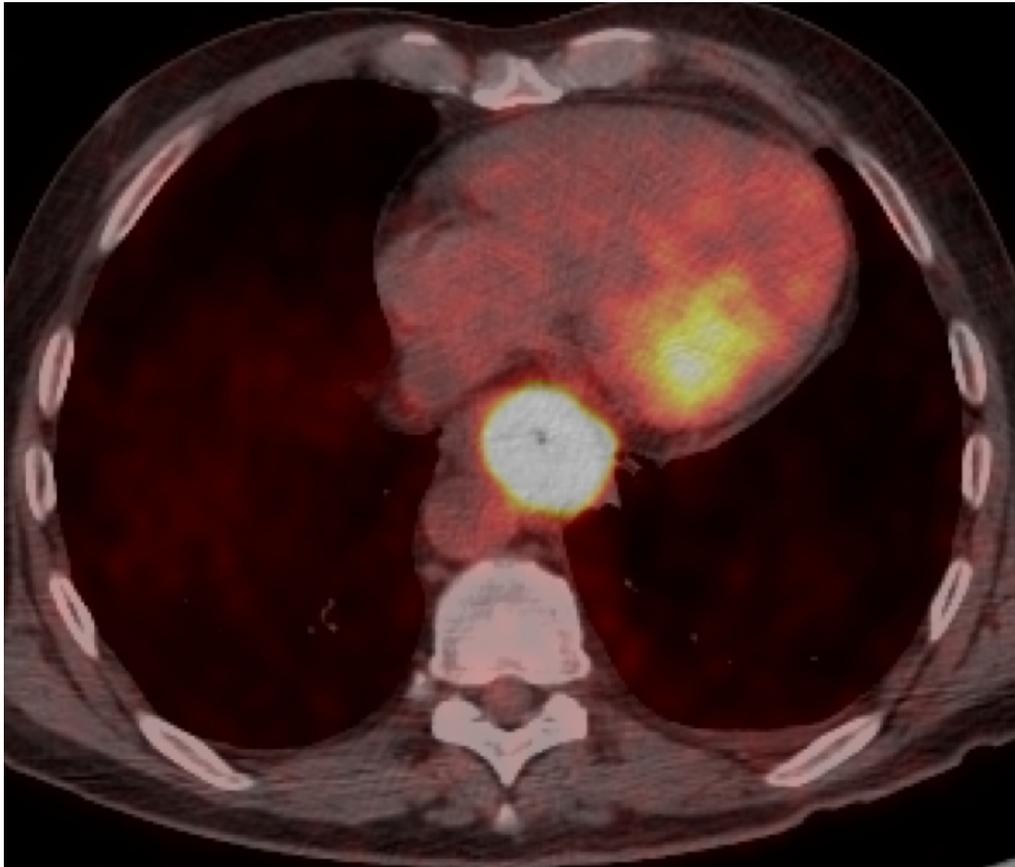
Example of a fused PET/CT axial image showing a distal oesophageal adenocarcinoma. PET images have been co-registered with the CT images. The oesophagus is circumferentially thickened at the level of the ventricles and the primary tumour is intensely FDG-avid. The image also shows FDG-uptake in the myocardium.
